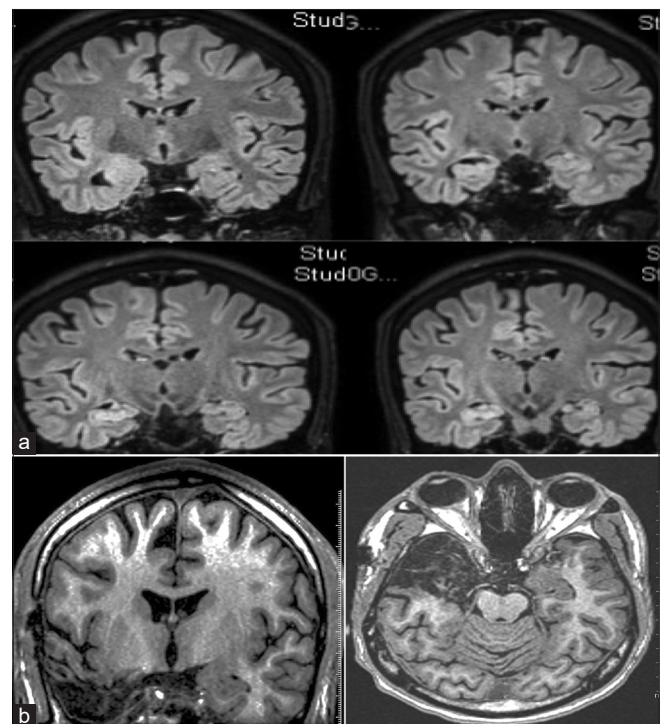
(a) Preoperative coronal FLAIR MRI Images showing right hippocampal sclerosis. (b) Postoperative T1W MRI images showing standard temporal lobectomy
